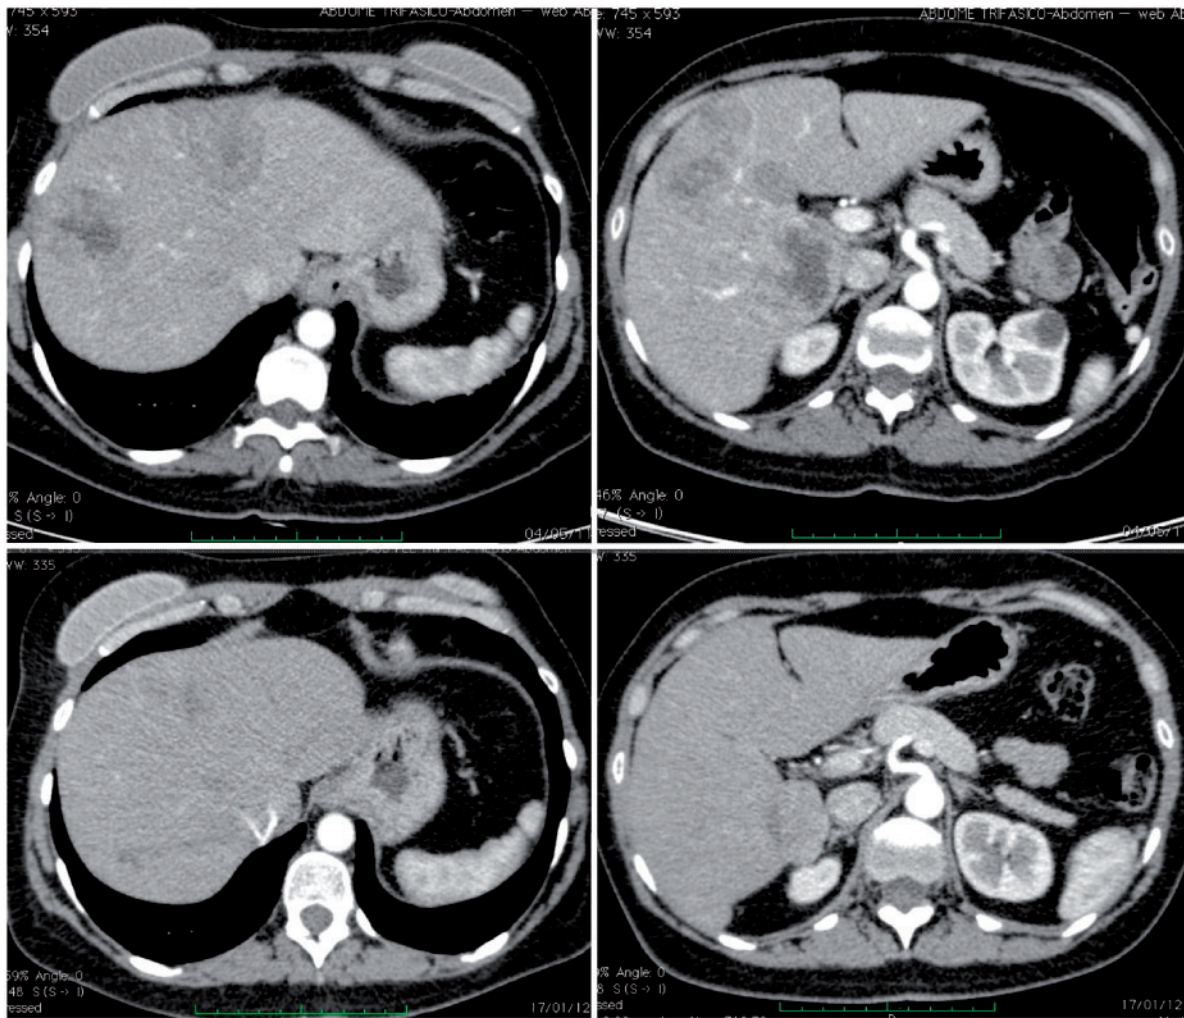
Abdominal contrast-enhanced CT before (top) and after (bottom) the first hepatic TACE procedure, showing a robust response in the metastatic hepatic lesions during the arterial phase.
